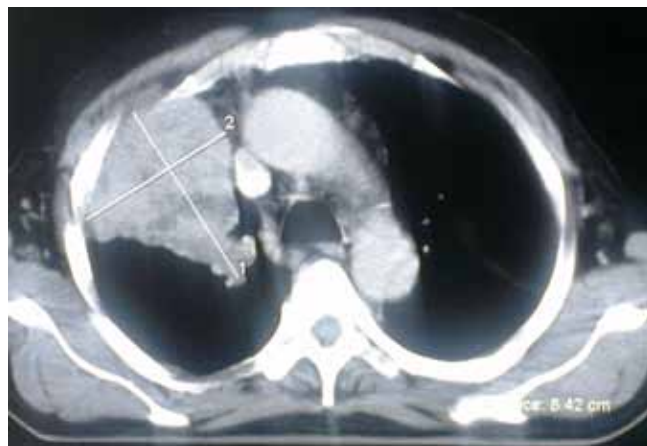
CT scan thorax in January 2013-Large solid mass in right upper lobe with calcification in superior mediastinum.
